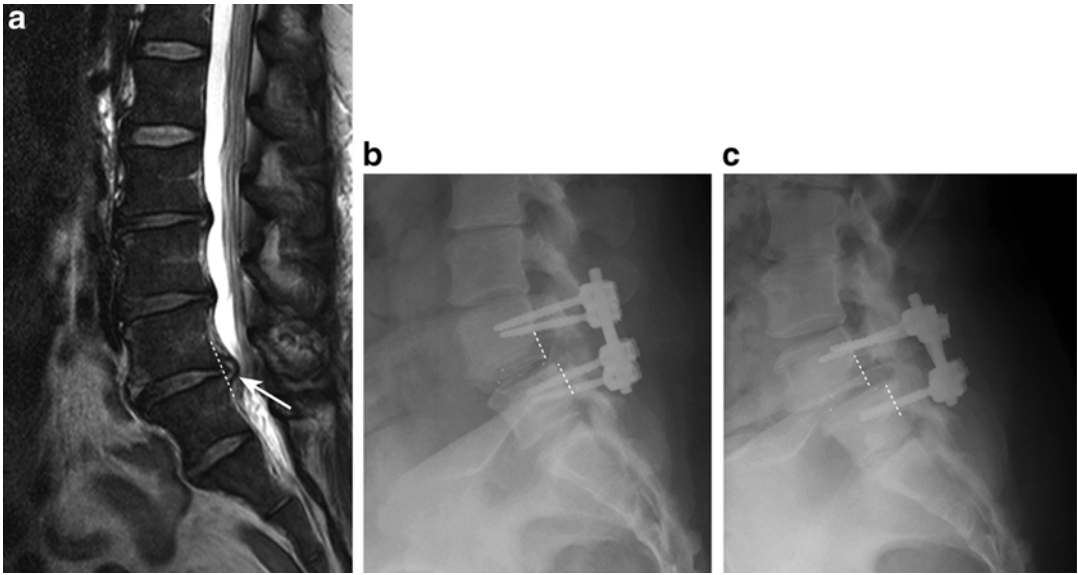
Post-operative spondylolisthesis. (a) Pre-operative sagittal T2W MRI demonstrates normal alignment at L4–5 (*dashed line*). There is central spinal canal stenosis related to a disc protrusion (*arrow*). (b) Two
